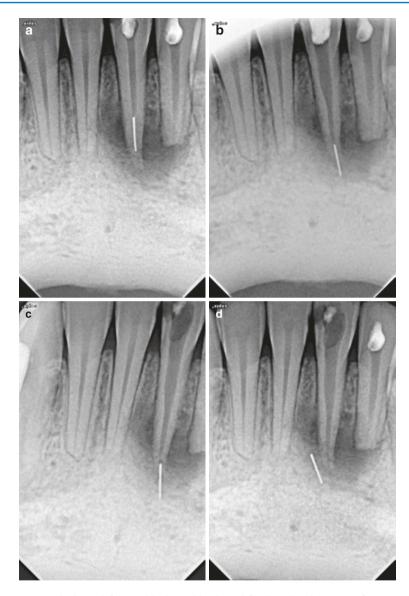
(a) The lower left central incisor with a buccal fistula and an instrument fragment at the apical third of the root canal was referred for RCT. (b–d) Unsuccessful efforts to retrieve it with ultrasonics following exposure of its coronal segment and creation of a staging platform resulted in extrusion of the fragment to the periapical tissues. (e) The canal was instrumented to the desired working length, dressed with calcium hydroxide for 15 days, and eventually obturated with lateral compaction of gutta-percha and epoxy resin sealer (AH26, Dentsply DeTrey, GmbH, Konstanz, Germany), and the fragment was removed surgically. No resection of dental tissues was needed. (f) The scheduled recall clinical and radiographic follow-up at 1 year revealed uneventful healing (Courtesy of Dr. K. Kodonas)
